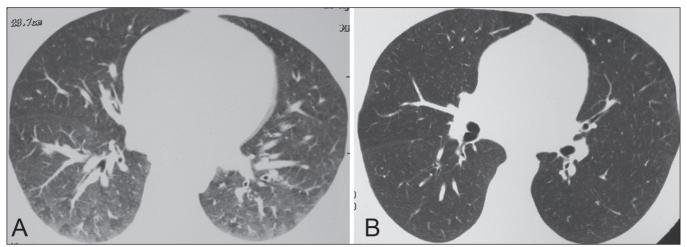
High-resolution computed tomography scan of the patient before treatment (A). Ground-glass opacities involving bilateral upper lobe apical and apicoposterior segments, lower lobe basilar segments showed a mosaic pattern. Total resolution of the infiltrates were seen after treatment (B)
